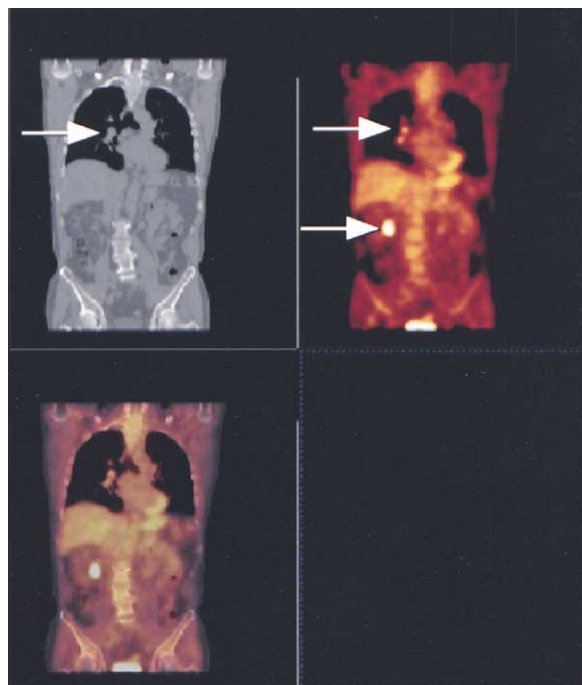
Image of a PET/CT study in a 65 yr old male. Study time was 40 minutes with injection of 10m Ci FDG. Primary tumor is in right lung with metastases in colon (arrows). Coronal, sagittal and transverse views are shown: CT (top left), PET (top right) and fusion of PET and CT (bottom). Courtesy of the University of Tennessee.
